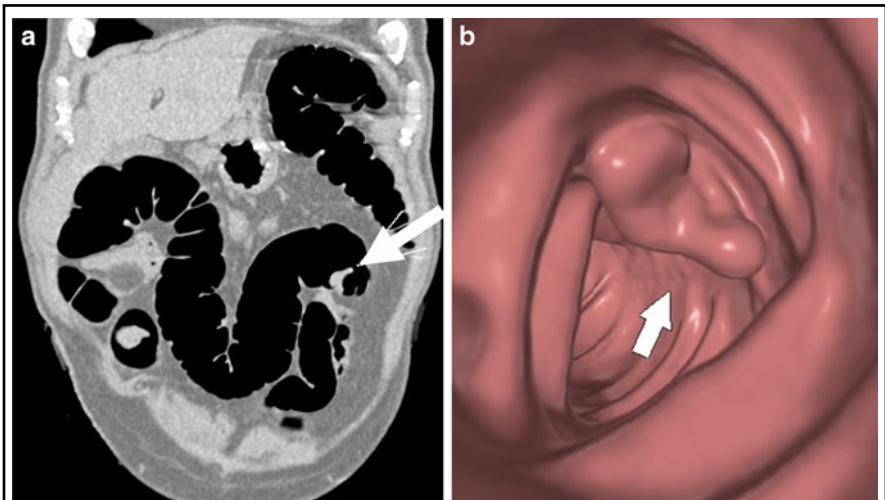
CT COLONOGRAPHY
